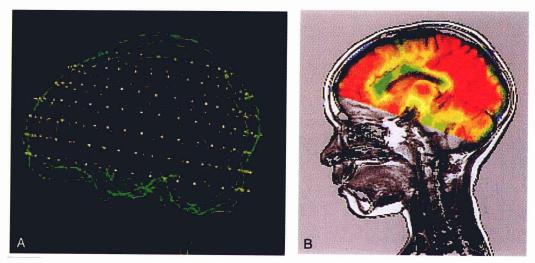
Screen display from a surface-fitting program. The sagittal contours represent the brain surface extracted from an MRI study. The dots are brain surface contours from axial images of positron emission tomography data. After initially positioning the two data sets interactively, the surfaces are fit to each other to minimize the volume between them.
